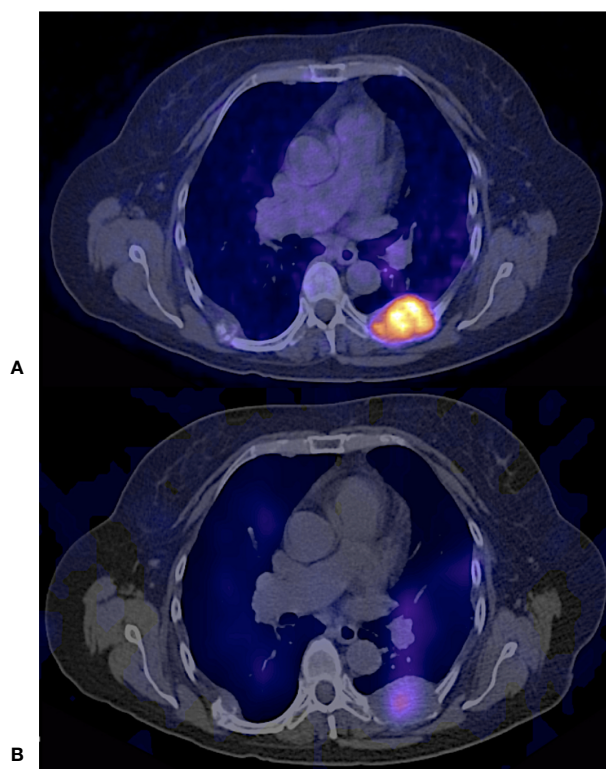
61 years old female with follicular thyroid carcinoma, insular differentiation (20%), treated with TT + RAI (cumulative dose 25900 MBq); Thyroglobulin 3922 ng/dl. Paravertebral implant. (A) ^{68}Ga - PSMA PET/CT avid lesion. (B) ^{131}I – SPECT/CT showed diffuse uptake of the radiotracer.
